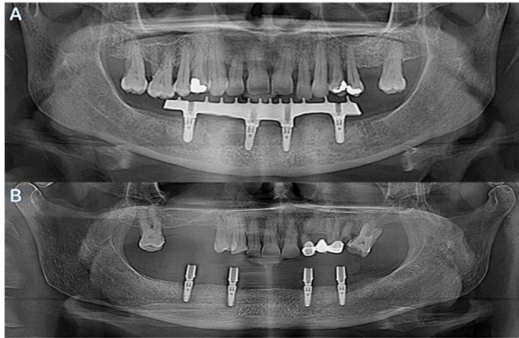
Panoramic radiographs: final hybrid prostheses intraorally (A) titanium (B) PEEK.
